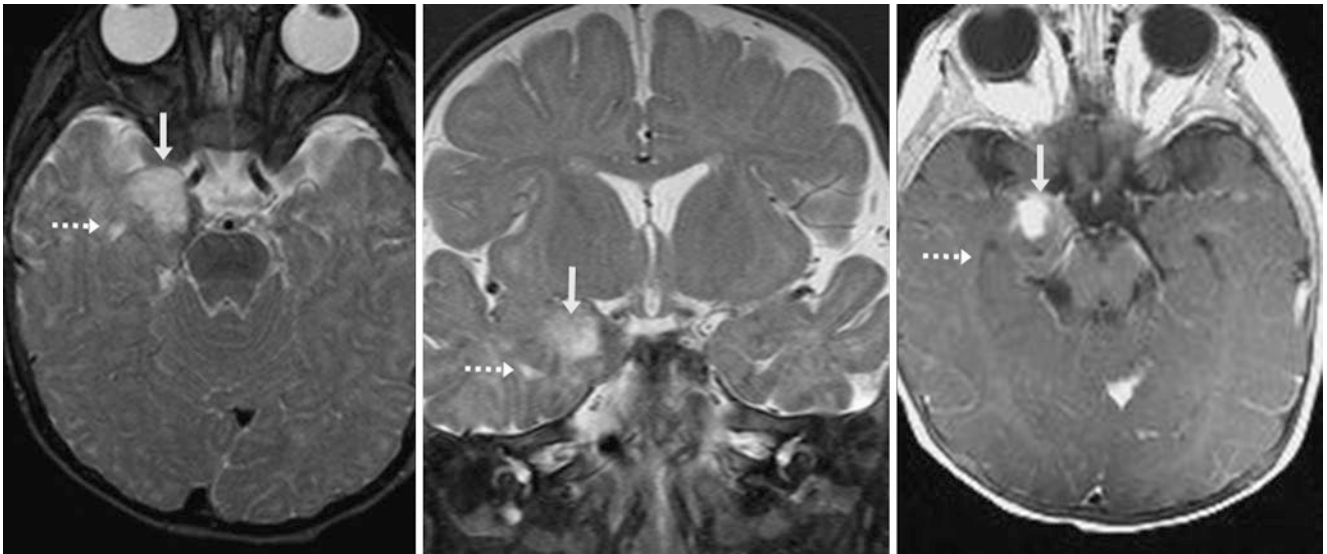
Comparison case of ganglioglioma. In an 8 month old with seizures, a noncontrast 3 T MRI with axial (*left*) and coronal (*middle*) T2WIs depicted a potentially cystic lesion; the temporal horns (*dashed arrows*) were normal. However, the lesion's internal signal was less
